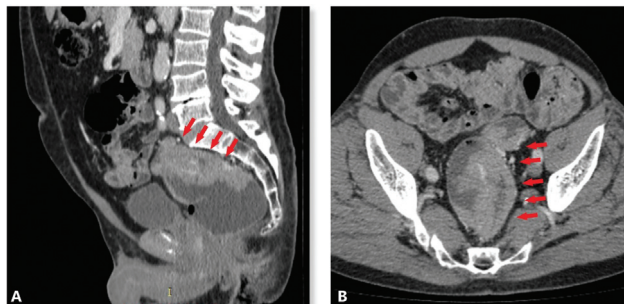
Abdominal CT scan showing a large rectal tumor. (A) Sagittal view. (B) Axial view.
